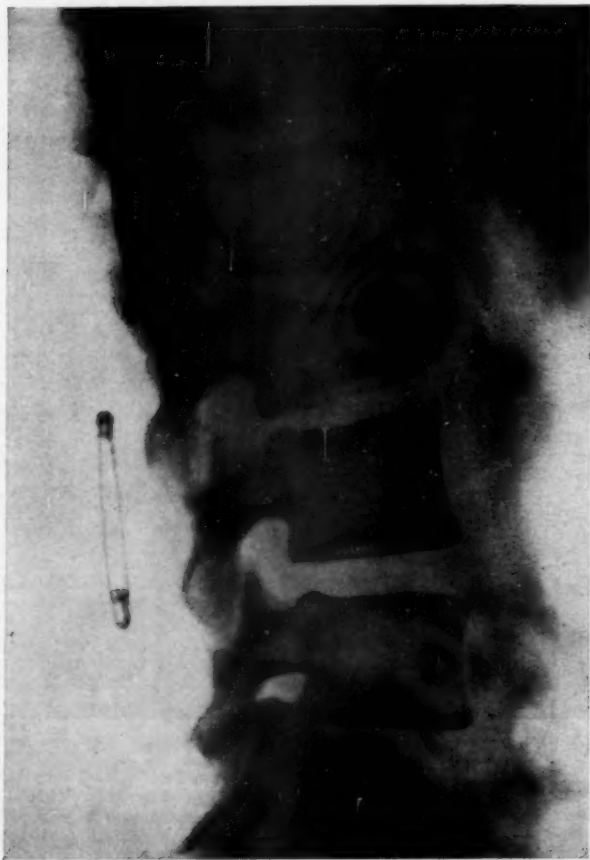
Radiograph of lumbar spine, lateral view.
